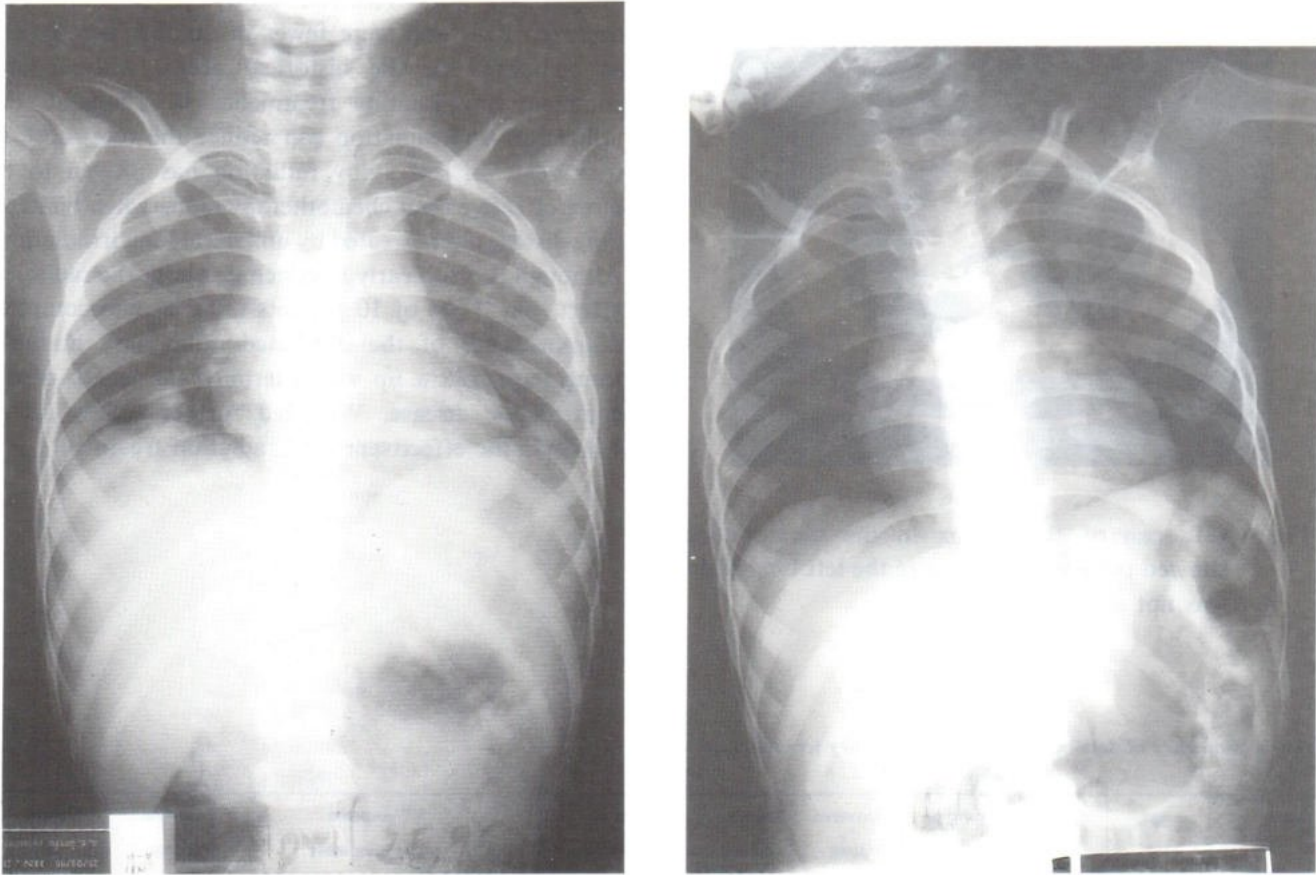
Plain film of the chest before and after irradiation of 2520 cGy at the right lung field combined with chemotherapy.
